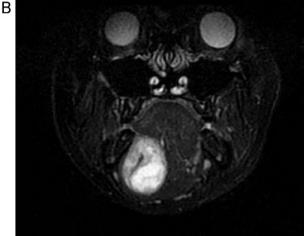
T2-weighted magnetic resonance imaging showing inhomogenous mass. A: axial view. B: coronal view.
